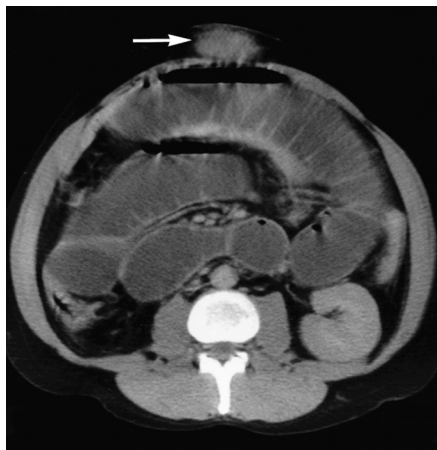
Small intestinal obstruction. A section through the mid-abdomen from a computed tomography (CT) scan shows dilated, mainly fluid-filled, small intestinal loops. The obstruction was because of an incarcerated paraumbilical hernia, the edge of which can be identified (*arrow*). (From Adam A, et al. *Grainger and Allison’s diagnostic radiology*. 5th ed. Edinburgh: Churchill Livingstone, 2008, Fig. 32-37.)
